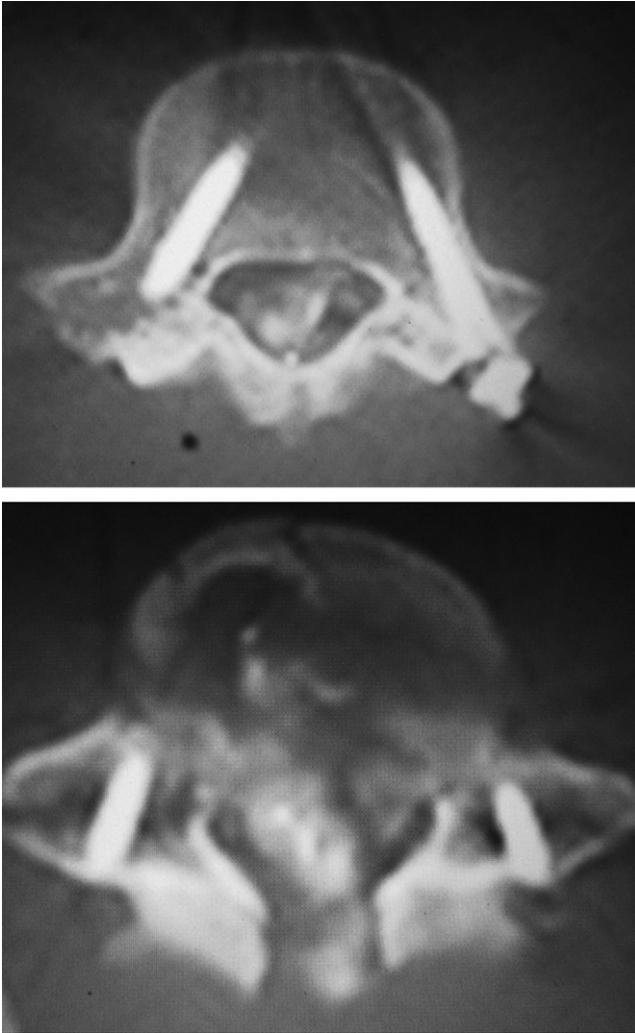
(Top) Postoperative CT scan showing position of the L4 pedicle screws. (Bottom) Postoperative CT scan showing position of the L5 pedicle screws, decompression of the spinal canal, and removal of the bullet fragments. CT, computerized tomography.
